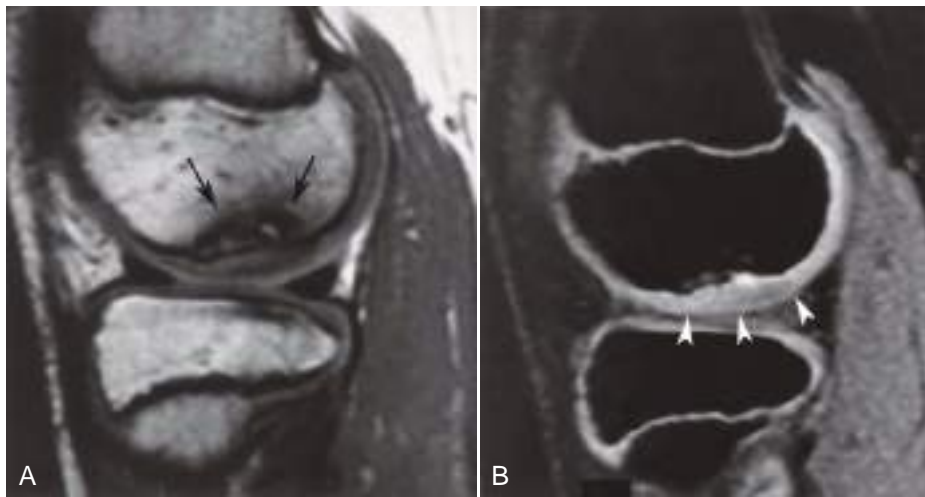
Osteochondritis dissecans with intact overlying articular cartilage. (A and B) Sagittal T1-weighted (A) and fat-suppressed spoiled gradient-echo (B) MR images show the osteochondral fracture lines (arrows in A). The overlying articular cartilage is intact (arrowheads in B).
